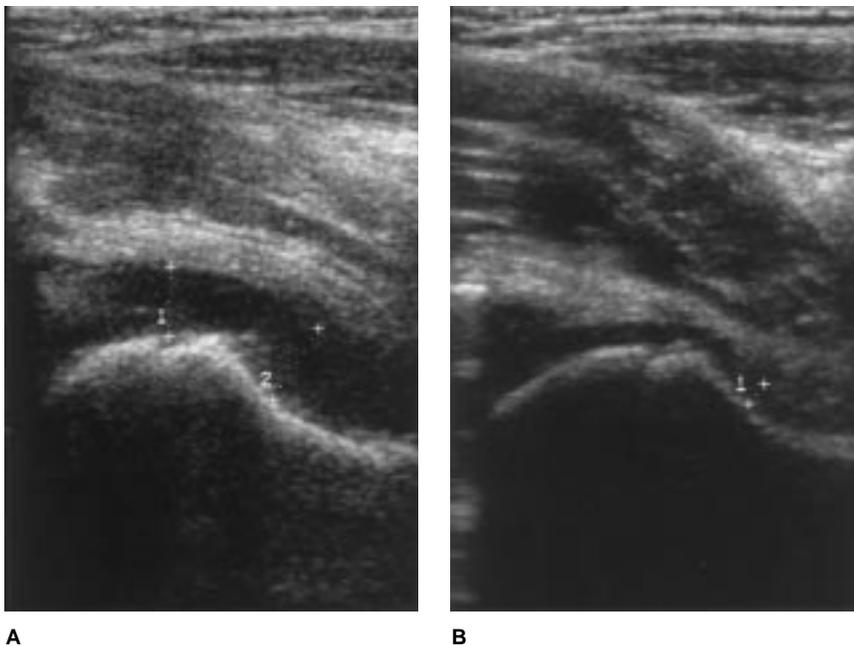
A, Longitudinal sonogram of the proximal left femur of a 7-year-old child with a septic hip joint. The joint space is increased to 5.6 mm at the physis (1) and 7.0 mm at the femoral neck (2). The capsule is also thickened. B, Comparison view of the normal right proximal femur demonstrates a 2.1-mm joint space at the level of the femoral neck (1).
